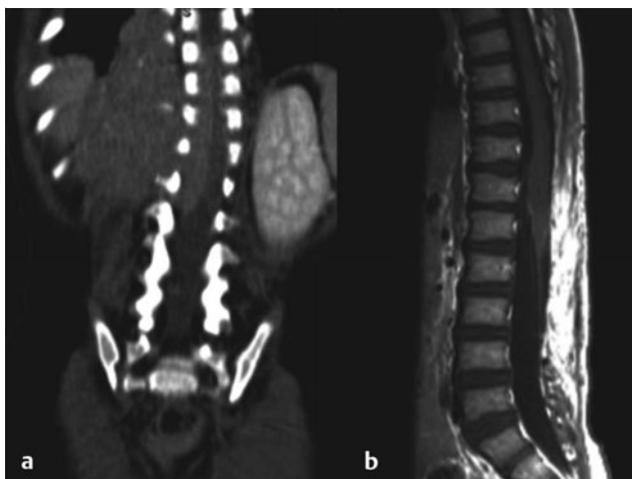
This 11-month-old boy presented with irritability and progressive paraparesis. (a) Computed tomographic scan with coronal reconstruction demonstrates a large thoracic paravertebral mass extending through multiple neural foramina, with spinal cord compression. Multilevel laminectomy rather than laminoplasty was performed because of bone infiltration. Neuroblastoma. (b) Sagittal postcontrast magnetic resonance image shows moderate kyphotic deformity, no evidence of tumor.
